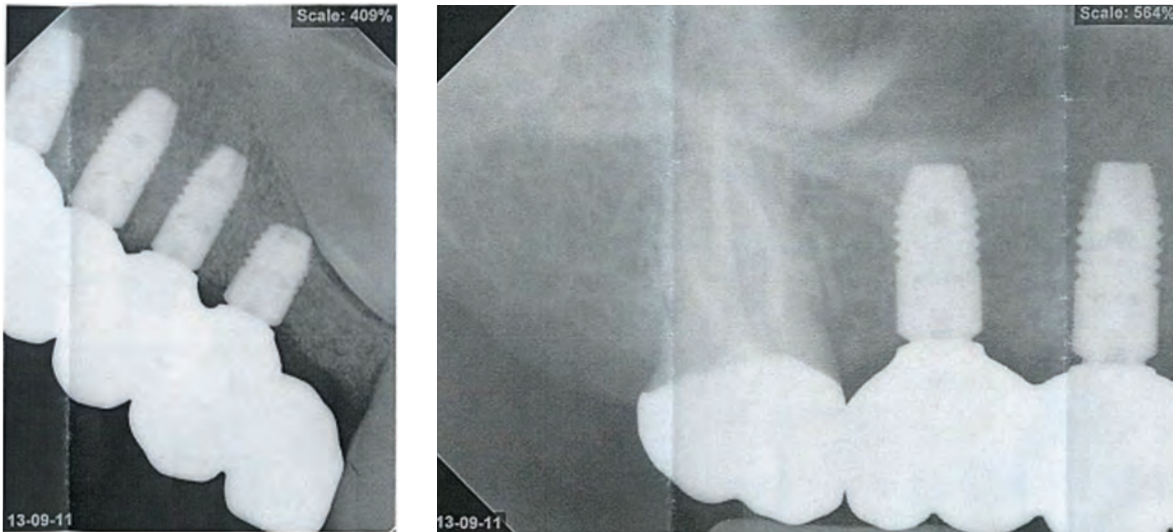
and B(below). 3 months post-restorative x-ray demonstrating excellent healing of the implants and relationship of implant 12 to the crown of impacted tooth 13.
